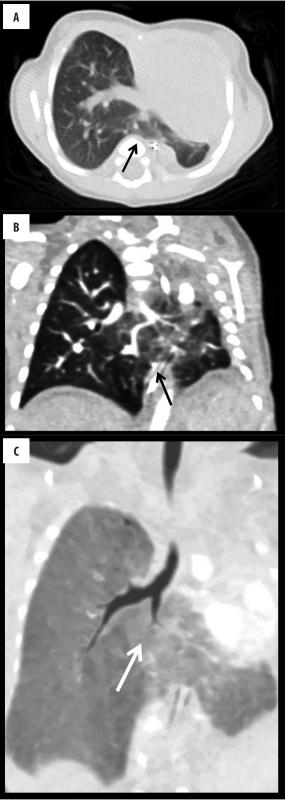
A transverse CT image (A) and an MPR coronal image (B) depicted the fusion of the posterior parts of the right and left lungs around the ventral esophagus (black arrows). A coronal MinIP image (C) demonstrating that the left hypoplastic bronchus had deviated towards the isthmus (white arrow).
